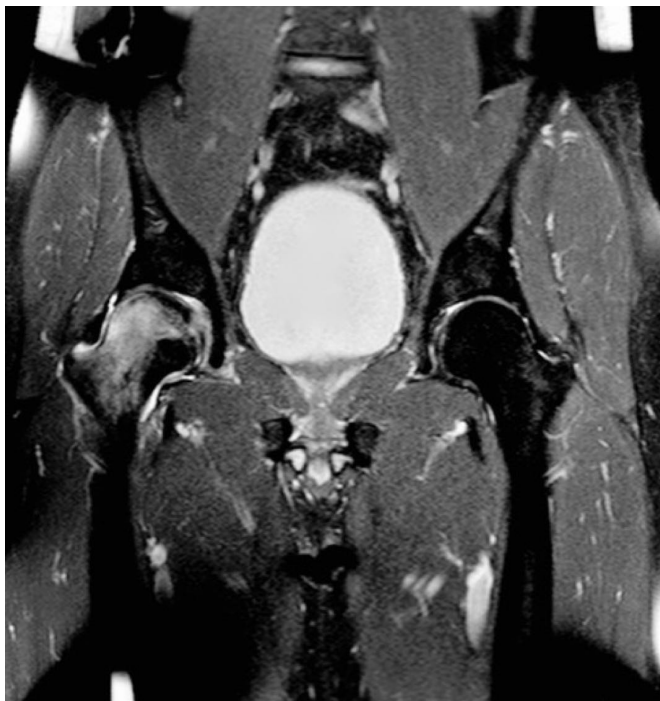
MRI scan of both hips taken at 3 weeks after initial presentation. T2 weighted images show bone marrow oedema of the right femoral head extending to the intertrochanteric area with joint effusion.
